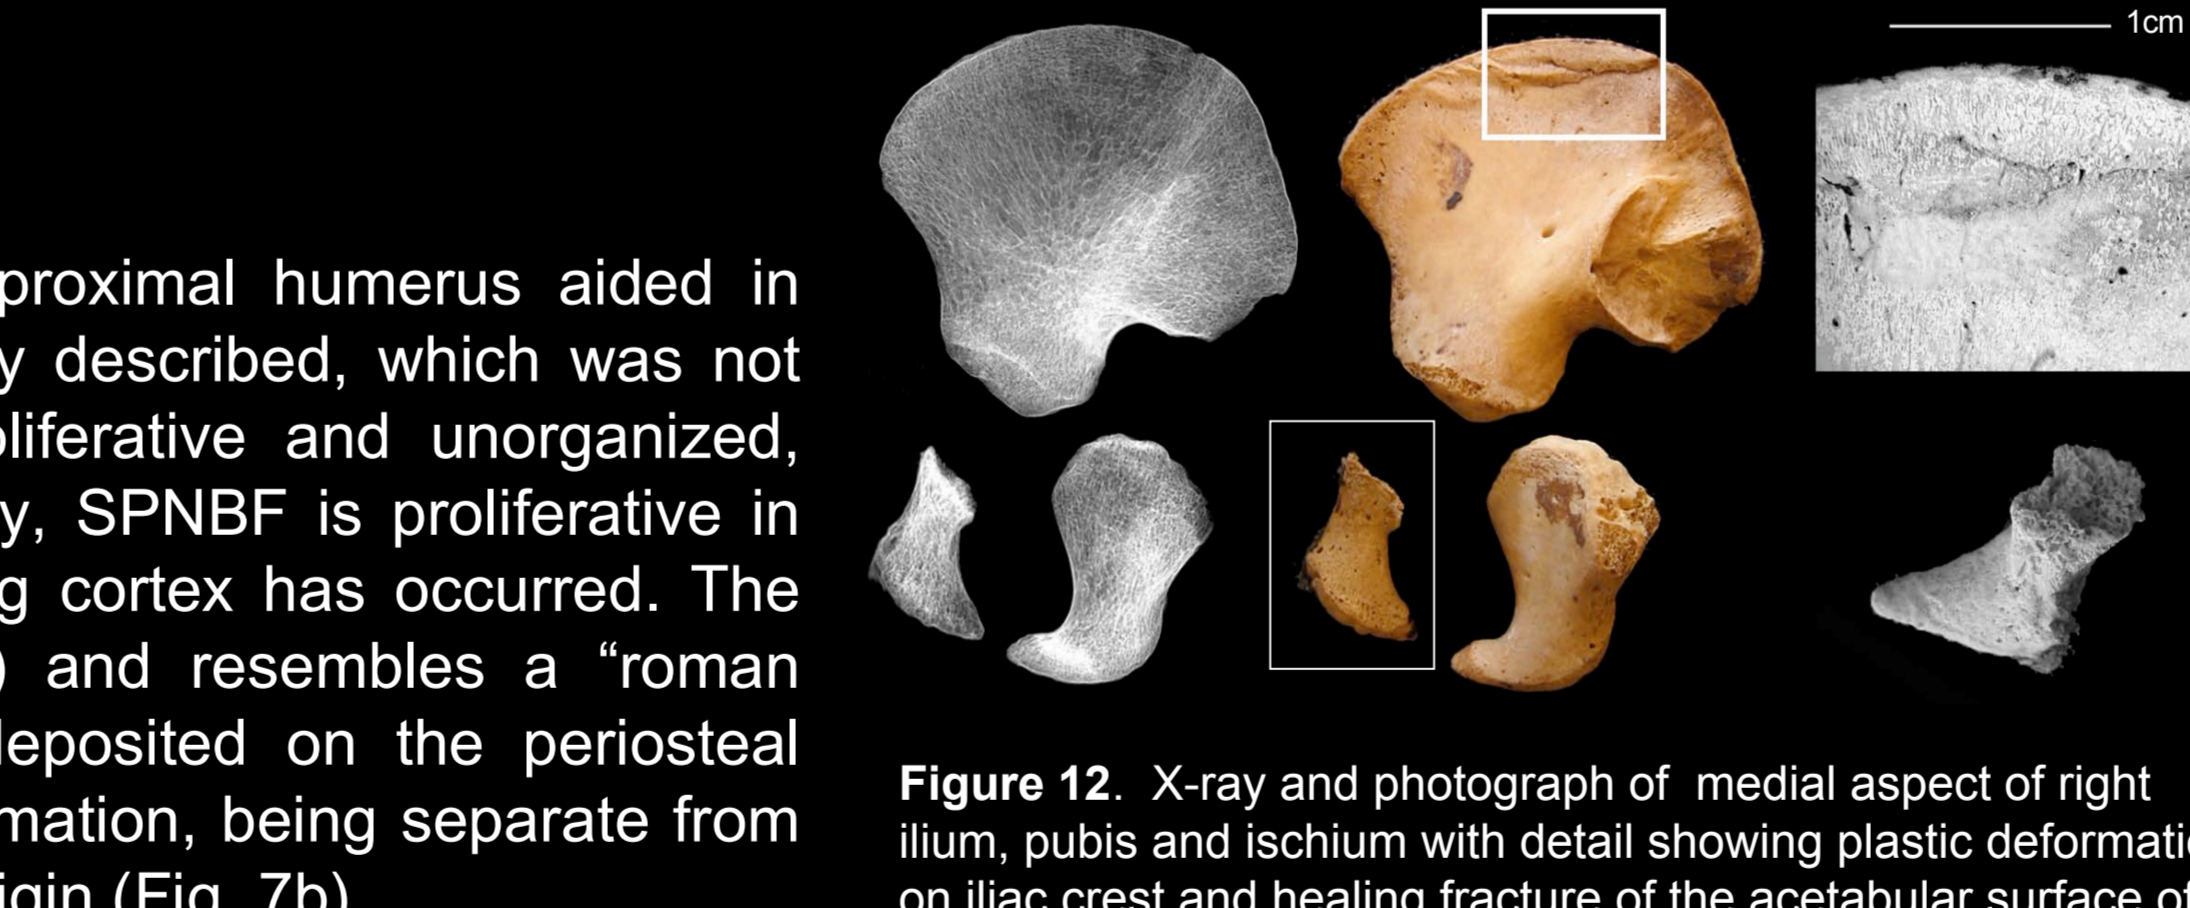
X-ray and photograph of medial aspect of right ilium, pubis and ischium with detail showing plastic deformation on iliac crest and healing fracture of the acetabular surface of the pubis (lateral view).
